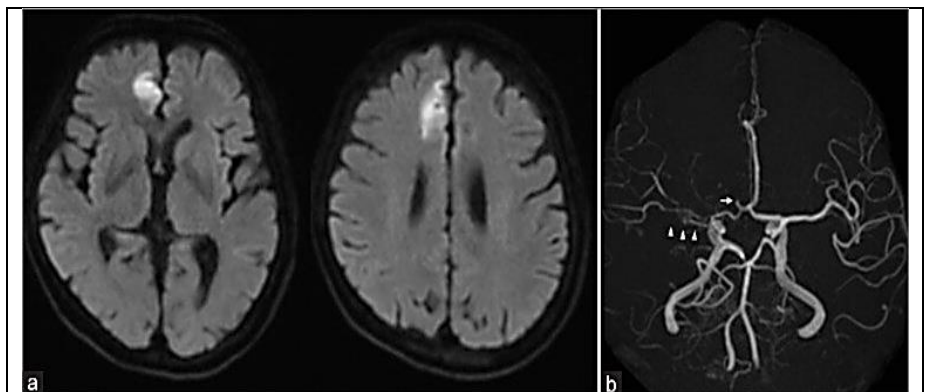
(a) Diffusion-weighted imaging of the right anterior cerebral artery on magnetic resonance imaging revealed a cerebral infarction. (b) Brain magnetic resonance angiography revealed a right A2 blockage (white arrow) and inadequate blood flow in the right middle cerebral artery (white arrowhead).
